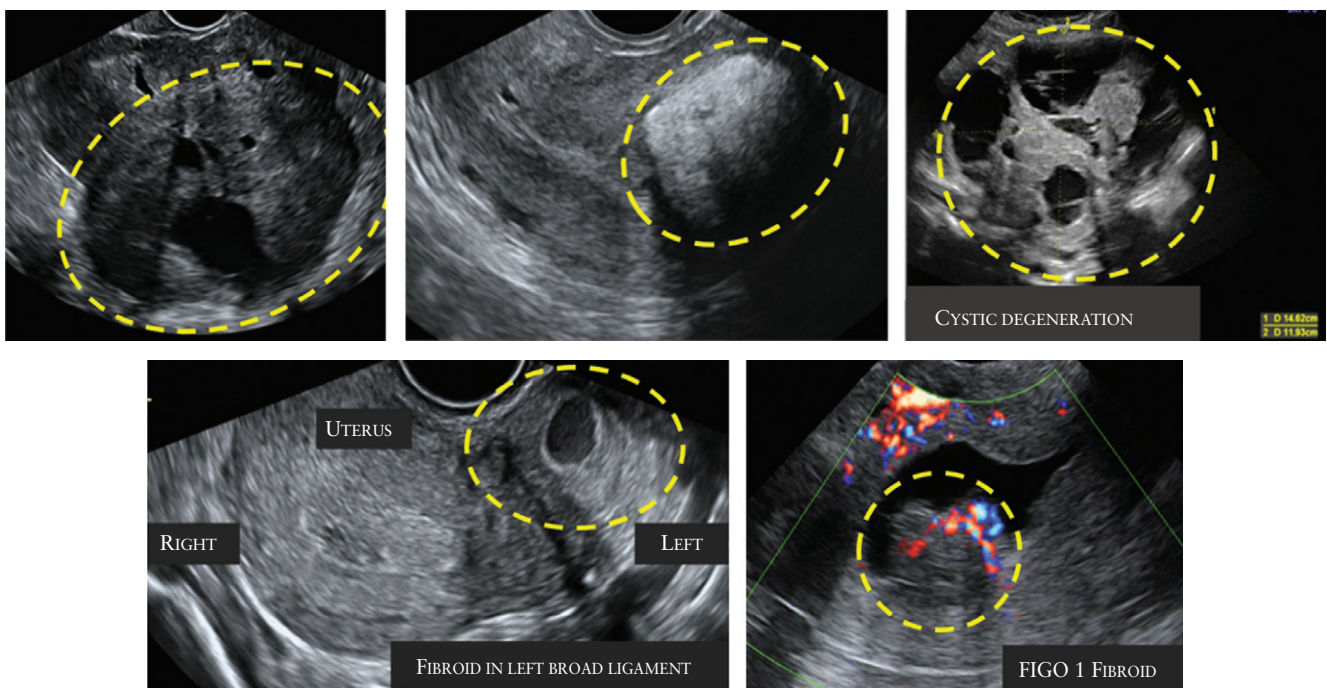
Ultrasound images showing fibroids with atypical sonographic features. These fibroids have non-uniform echogenicity and intralesional anechoic cysts, and some have areas with hyperechogenicity. The FIGO type 1 fibroid (bottom right) has an irregular outline.
